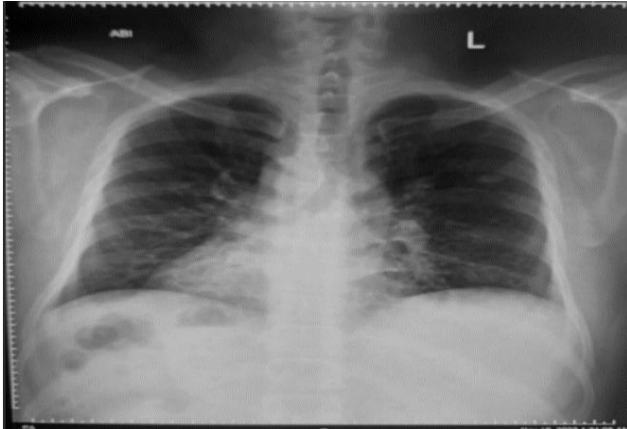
Chest X-ray of dextrocardia.
